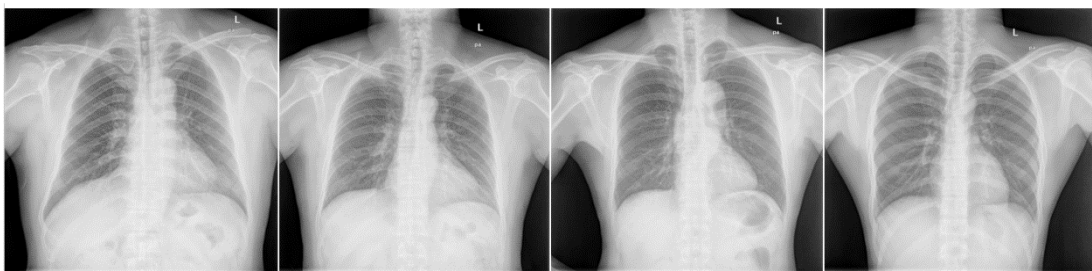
Samples of Chest X-ray dataset
